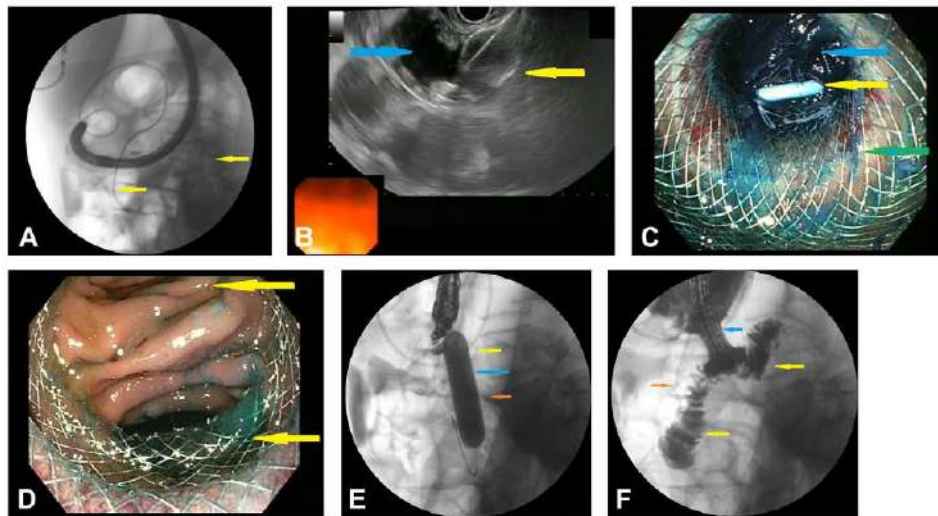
Endoscopic, radiologic, and endosonographic images of steps of EUS-guided gastroenterostomy. A, Radiographic view shows a nasocystic tube advanced over a guidewire (yellow arrows) into the proximal jejunum for water/methylene blue instillation and distention of jejunal loop. B, EUS views showing the distended jejunal loop (blue arrow) after instillation and the deployed distal flange of the lumen-apposing metal stent (LAMS; yellow arrow). C, Endoscopic image after LAMS deployment showing the jejunal loop with methylene blue (blue arrow), the nasocystic tube advanced into the jejunum (yellow arrow), and the proximal end of the LAMS as seen from the stomach (green arrow). D, Endoscopic view showing the LAMS and the afferent and efferent loop of the jejunum (yellow arrows). E, Radiograph showing the LAMS being balloon dilated (blue arrow), showing an adequate deployment of the proximal (yellow arrow) and distal flange (orange arrow). F, Iodinated contrast is injected through the working channel of the endoscope while being placed into the LAMS (blue arrow), showing adequate refill of afferent and efferent jejunal loops (yellow arrows). Note the nasocystic irrigation tube (orange arrow) is placed in close vicinity of the created anastomosis.
